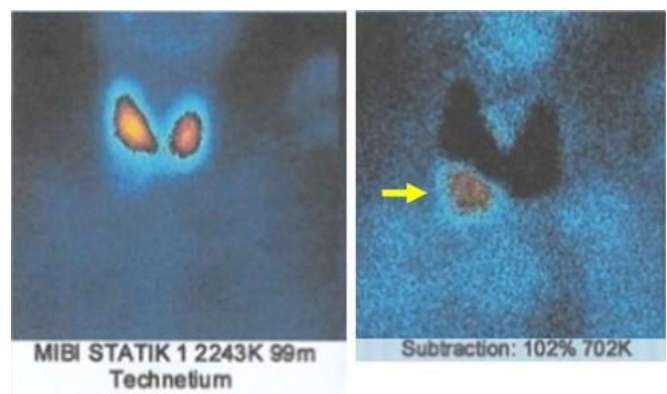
Parathyroid scintigraphy
